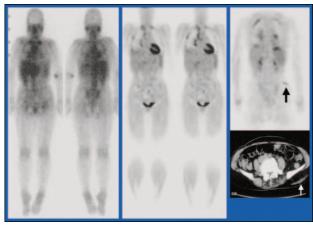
Comparison of ⁶⁷Ga scintigraphy (left) and ¹⁸F-FDG PET (middle) in the evaluation of sarcoidosis in a 63-year-old woman. PET was better than scintigraphy in terms of both sensitivity and specificity in identifying pulmonary and extrapulmonary lesion sites.
